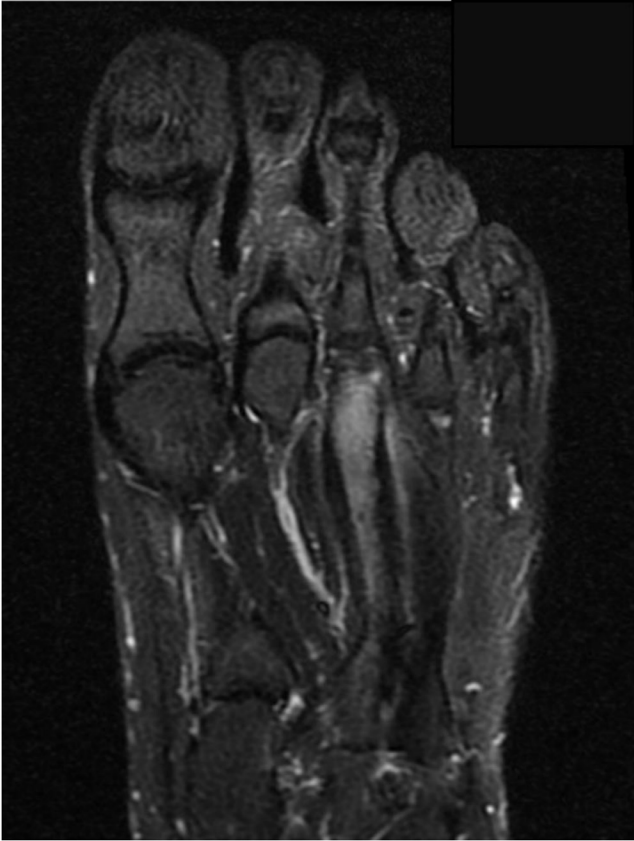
Axial view of MRI scan of the left foot. T1-weighted short tau inversion recovery (STIR) sequence showing diffuse edema of the cancellous bone in the diaphyseal portion of the left metatarsal.
